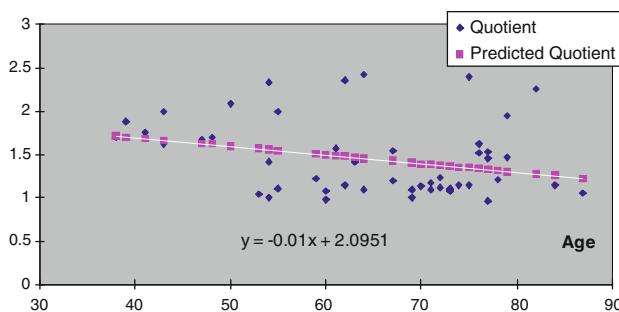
Decreasing heart/mediastinum ratio (H/M ratio) of MIBG scintigraphy in 50 patients with parkinsonism or dementia
